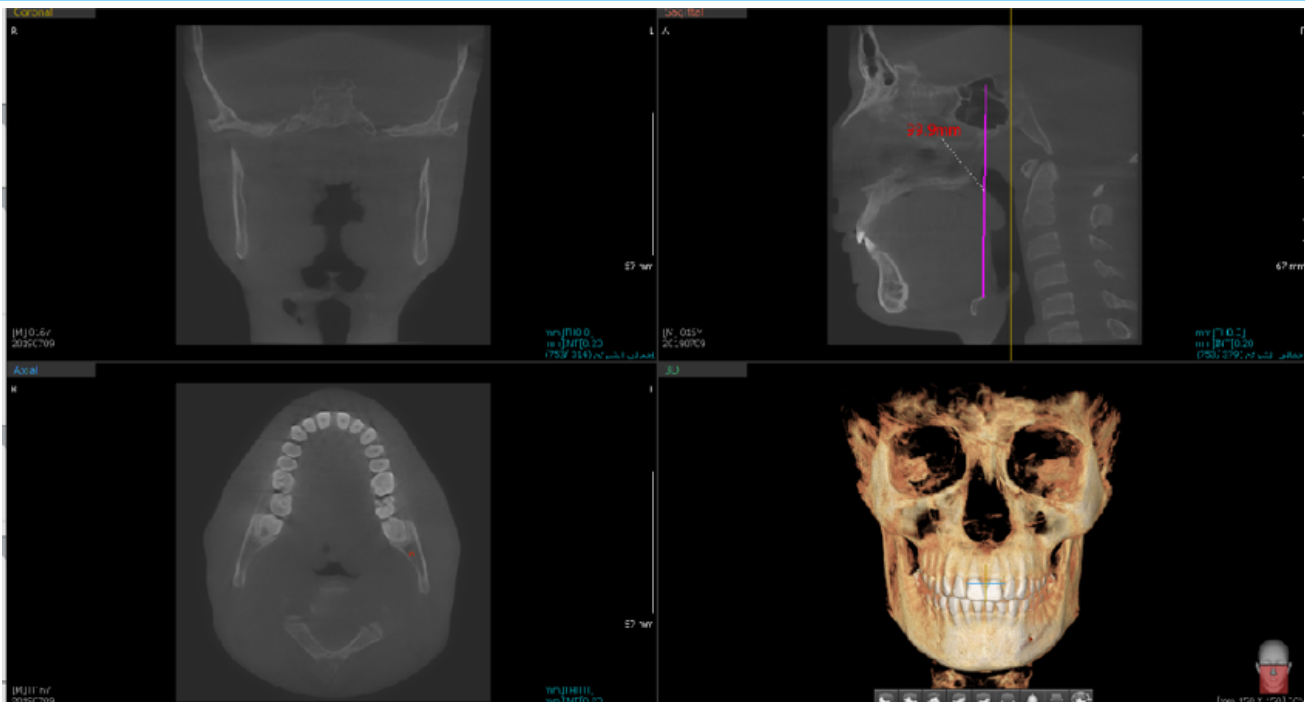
Construction of multiplanar windows of the CBCT
